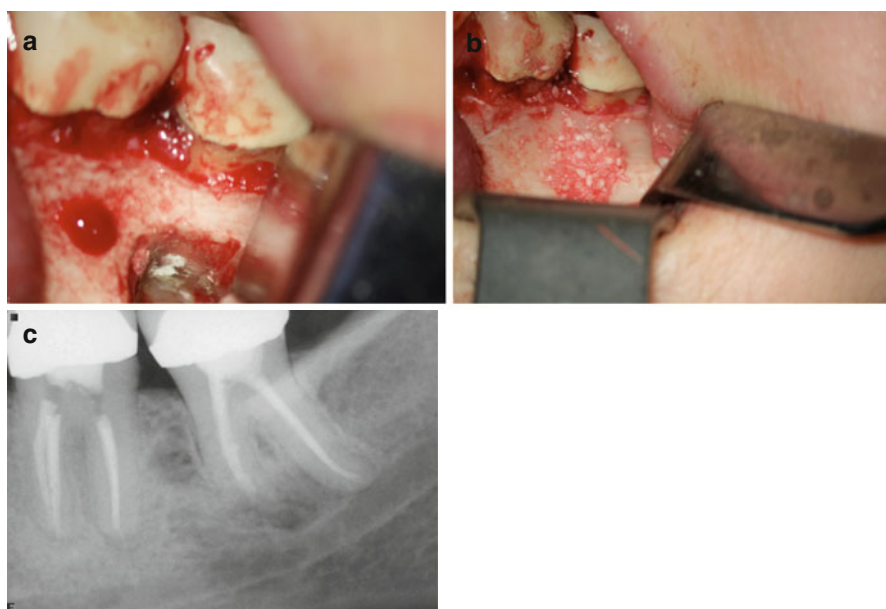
Continuation of case presented in Fig. 6.10: clinical picture demonstrating the MTA root-end filling (a). Periapical defect grafted with Puros™ allograft (Zimmer Dental, Warsaw, IN) material and before placing CopiOs™ membrane (b). Immediate postsurgical radiograph (c)
